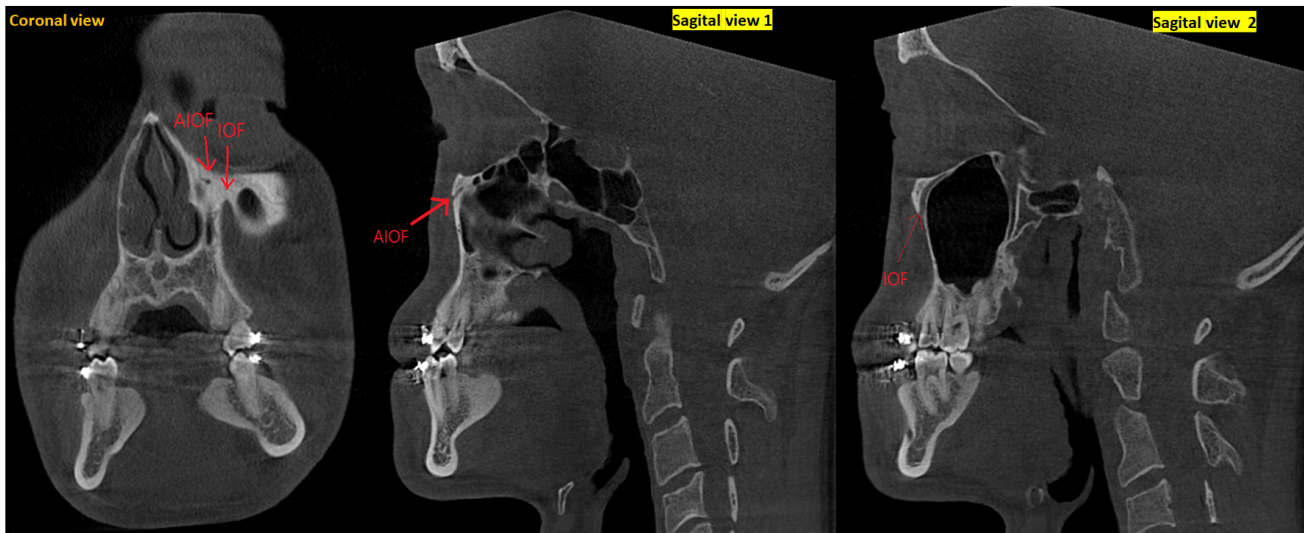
Cone-beam computed tomography in the planes showed Infraorbital foramen and accessory infraorbital foramen. AIOF, accessory infraorbital foramen; IOF, infraorbital foramen.
